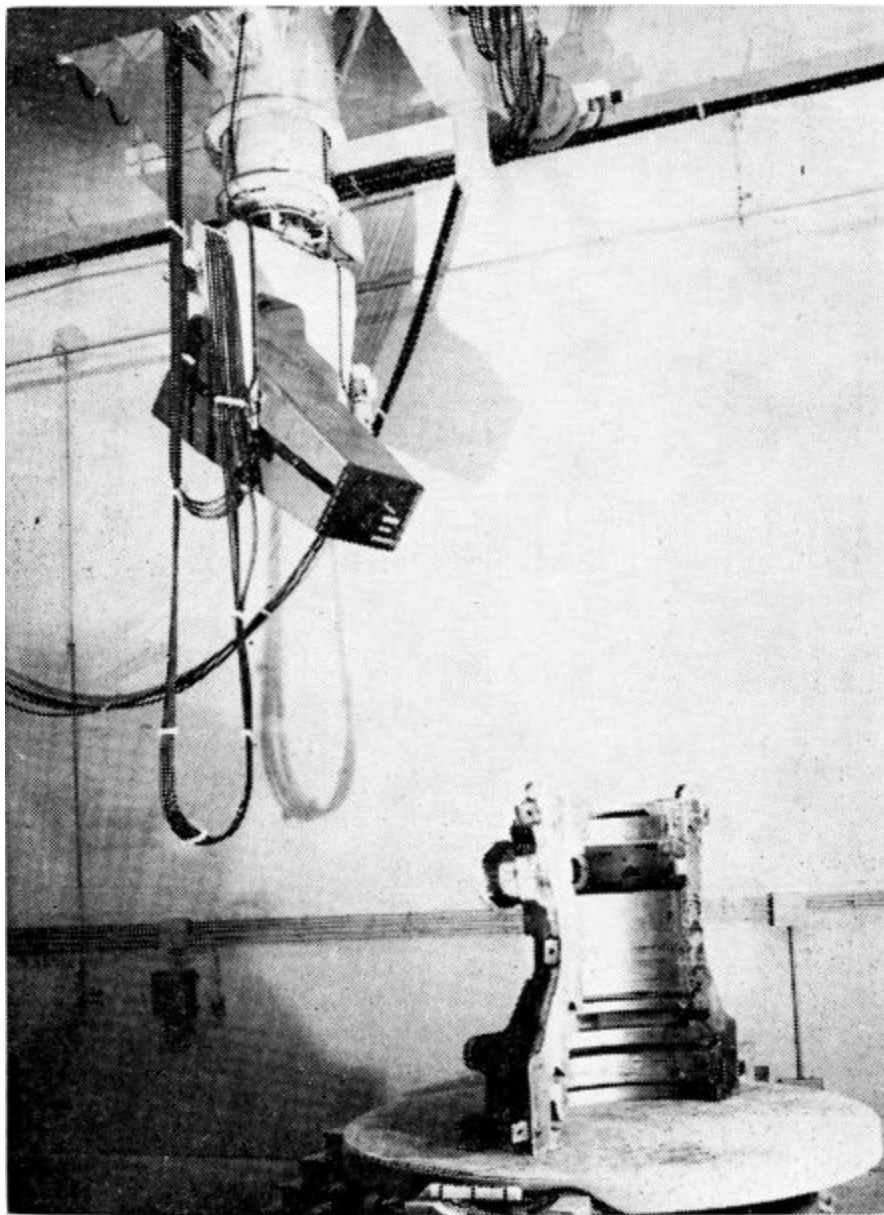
A Thomson-CSF 6MeV Industrial Radiographic Linear Accelerator.
